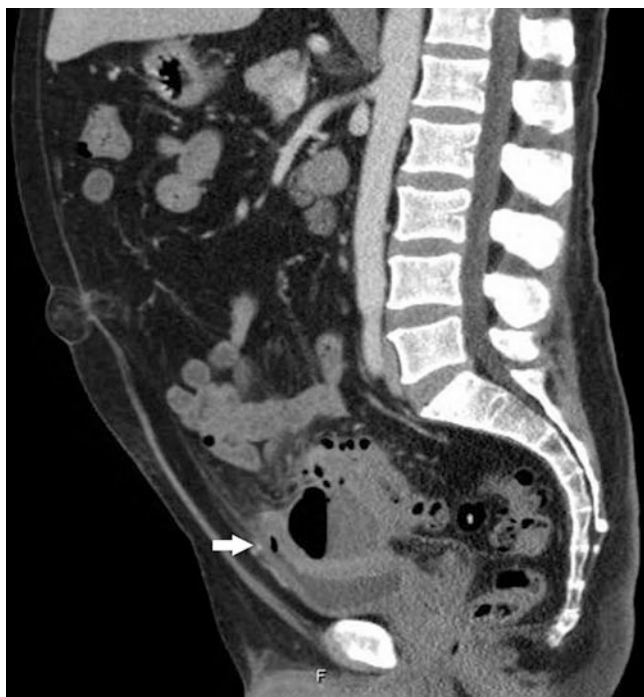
CT scan showing suspected colovesical fistula. Air within the bladder (solid white arrow)
